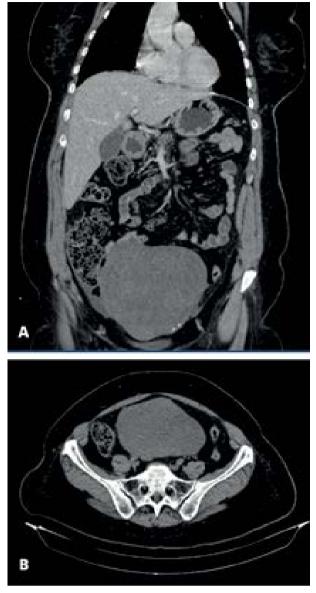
Computed tomography images. A) Coronal section showing solid, hypovascular tumor with some isolated peripheral foci of calcification. B) Axial cut showing bulky lesion in the pelvic region
